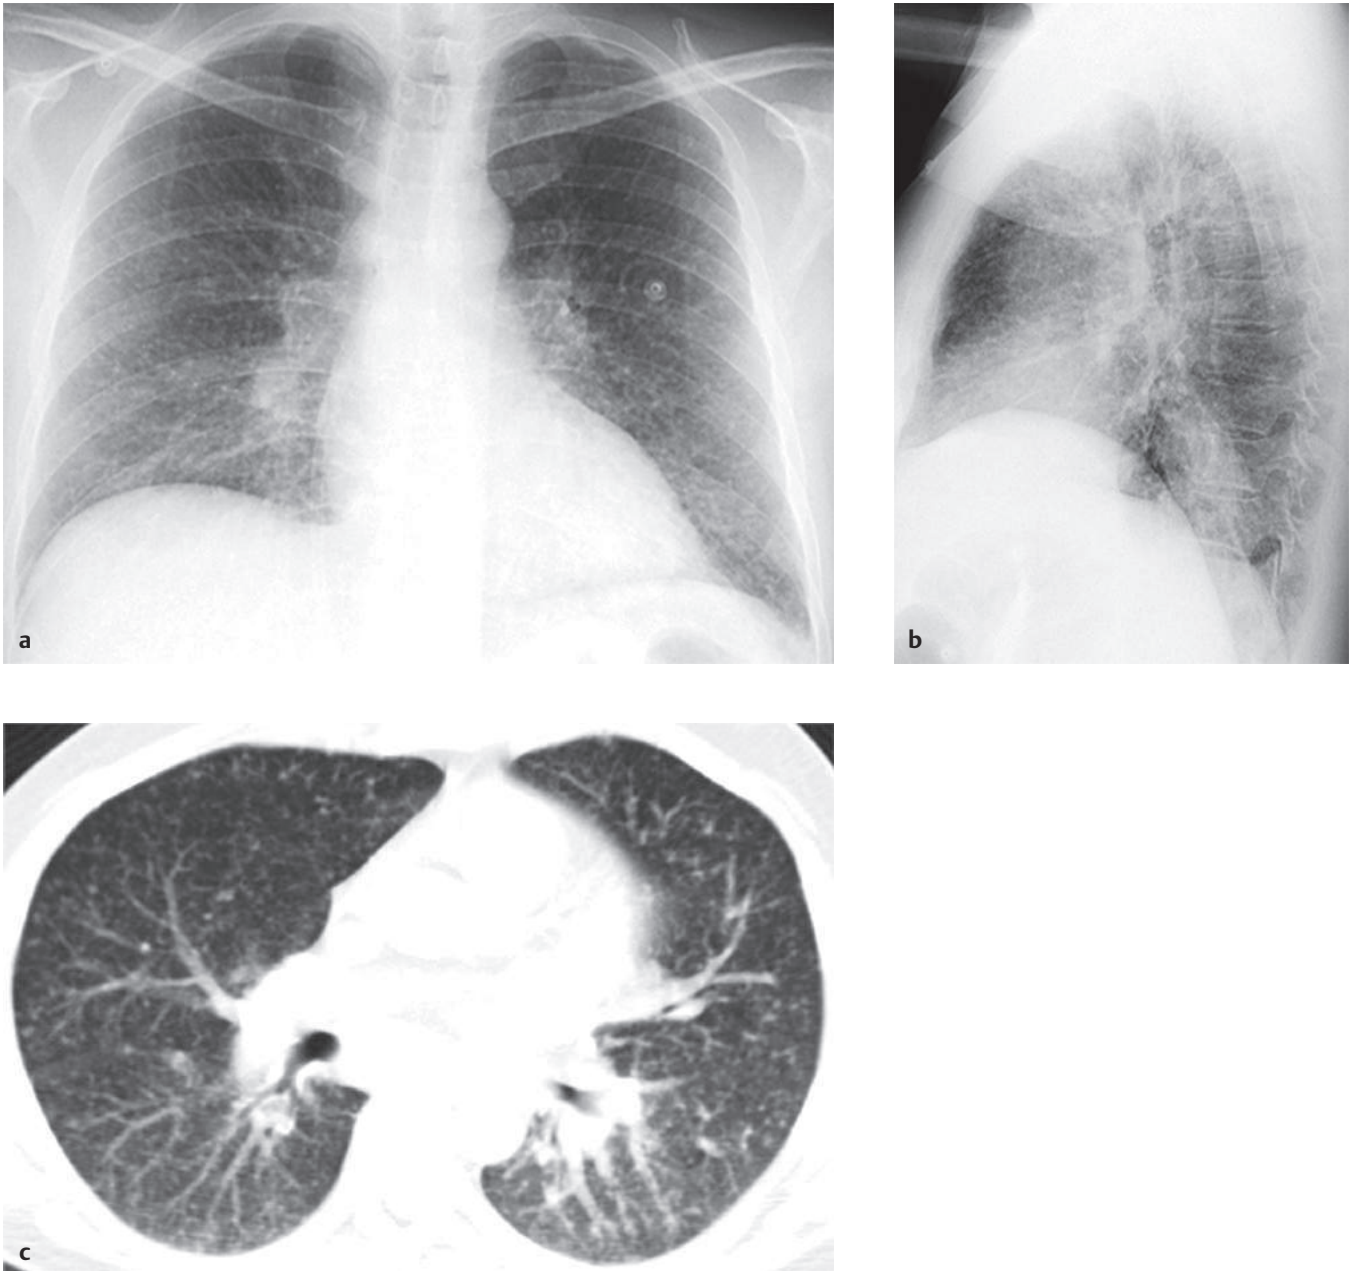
(a) Frontal and (b) lateral chest radiographs reveal diffuse bilateral tiny nodular densities, along with bilateral hilar fullness. (c) Axial computed tomography (CT) image in lung window demonstrates diffuse bilateral 1- to 3-mm miliary nodules in a random distribution.
